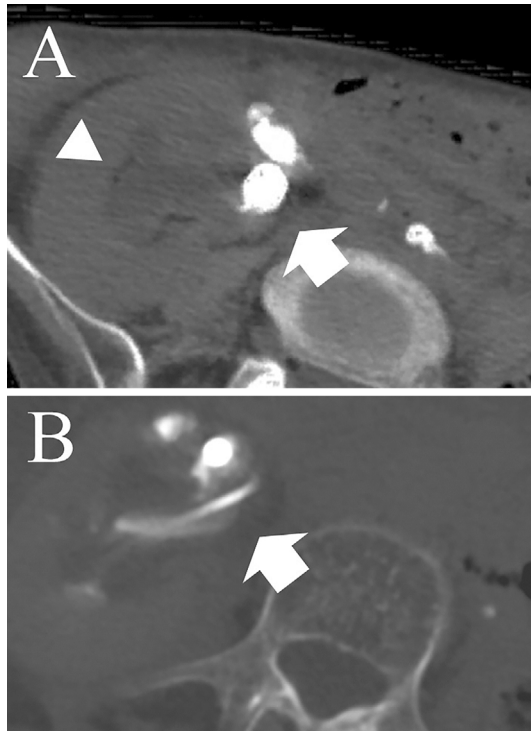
(A) Computed tomography revealed hydronephrosis of the right kidney (arrowhead). The white arrow indicates the stenotic lesion behind the coil. (B) After inserting the ureteral stent, the hydronephrosis improved. The white arrow indicates the inserted ureteral stent.
